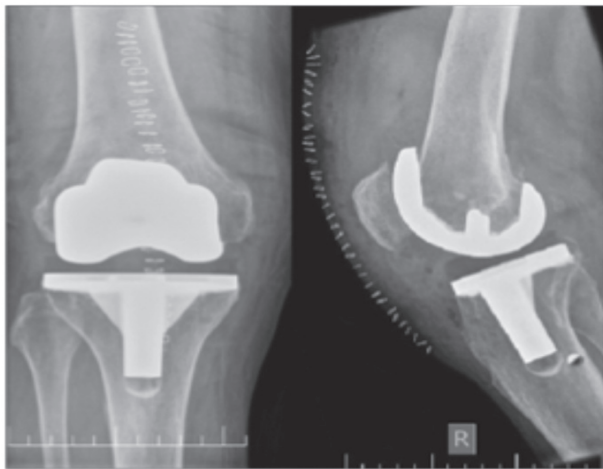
A Radiograph of TKA Using Implant PFC Sigma
